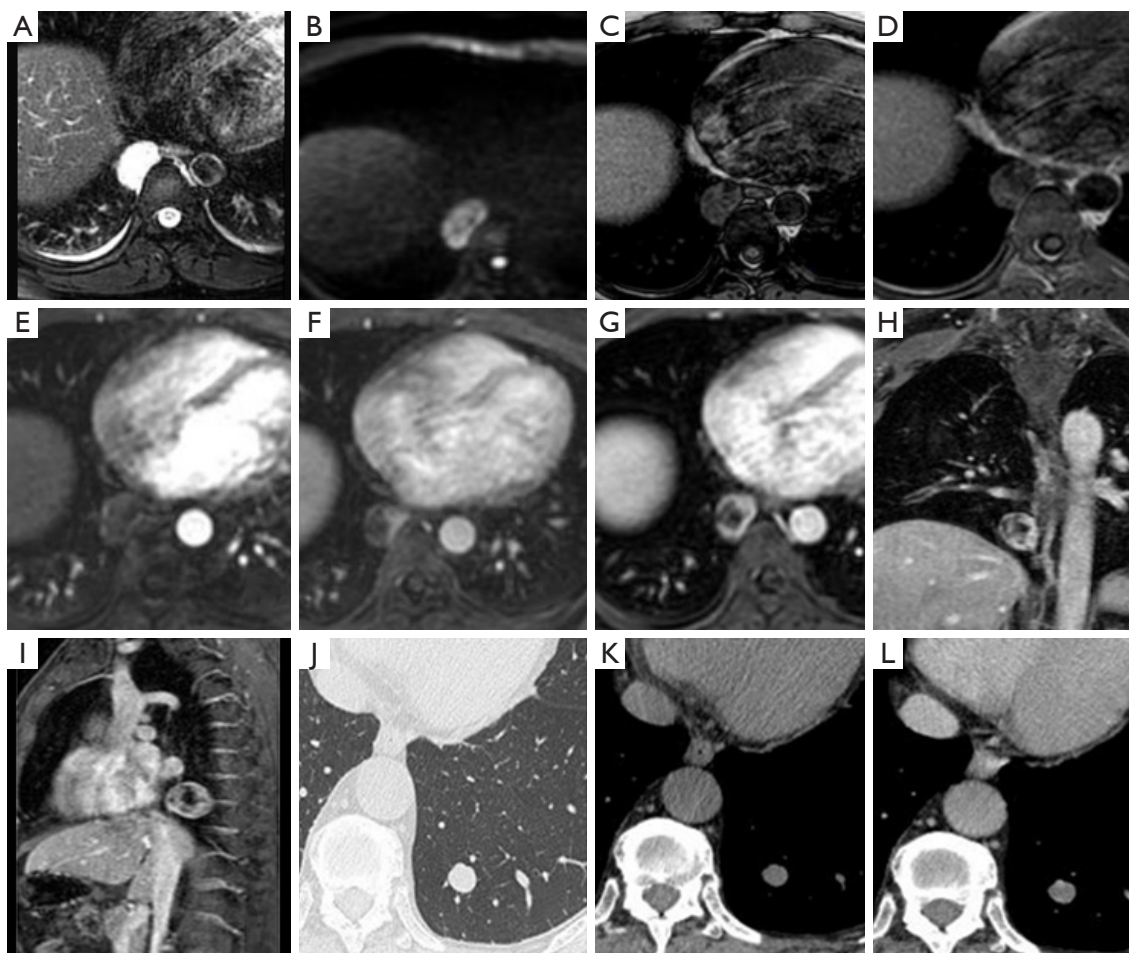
Images from Cases 3 (A-I: chest MRI scan) and 4 (J-L: chest CT scan). Case 3: A 31-year-old male with nodules beside the posterior mediastinum discovered in physical examination. (A-I) Chest MRI nonenhanced and enhanced scans. (A) Axial T2WI: a quasicircular smooth-edged shadow about 29 mm × 17 mm × 23 mm beside the posterior mediastinum of the right lower lobe and long T1 and T2 signals. (B) DWI: hyperintensity. (C,D) No signal diminution in positive or negative phase signals. (E-G) Enhanced scanning: dynamic-enhanced scans showing continuous uneven enhancement. (H) Coronary scan and (I) sagittal scan: lesions distinctly separated from surrounding tissues. Case 4: A 56-year-old male with nodules in left lower lobe identified in physical examination. (J-L) Chest CT nonenhanced and enhanced scans. (J) Lung window: quasicircular nodules, approximately 13 mm in diameter, observed in the posterior basal segment of the left lower lobe. (K) Mediastinum window: nodules of even density, with a CT attenuation value of about 28 HU. (L) Enhanced scan: mild enhancement during the arterial-venous phase, with a blood vessel running along the margin of the lesion. MRI, magnetic resonance imaging; CT, computed tomography; T2WI, T2-weight imaging; DWI, diffusion-weighted imaging; HU, Hounsfield units.
